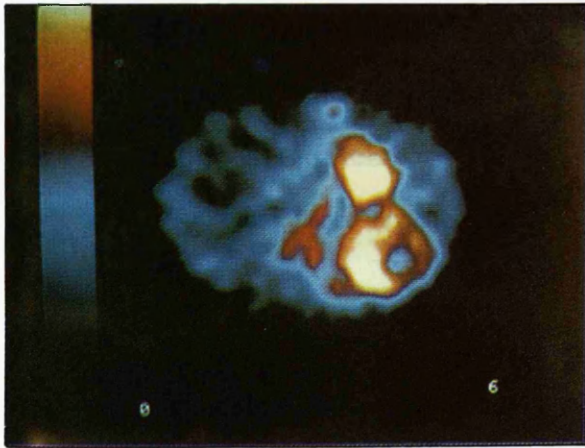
Single photo emission computerized tomography (SPECT) transaxial cuts showed the tumour uptake with central photopenia.
